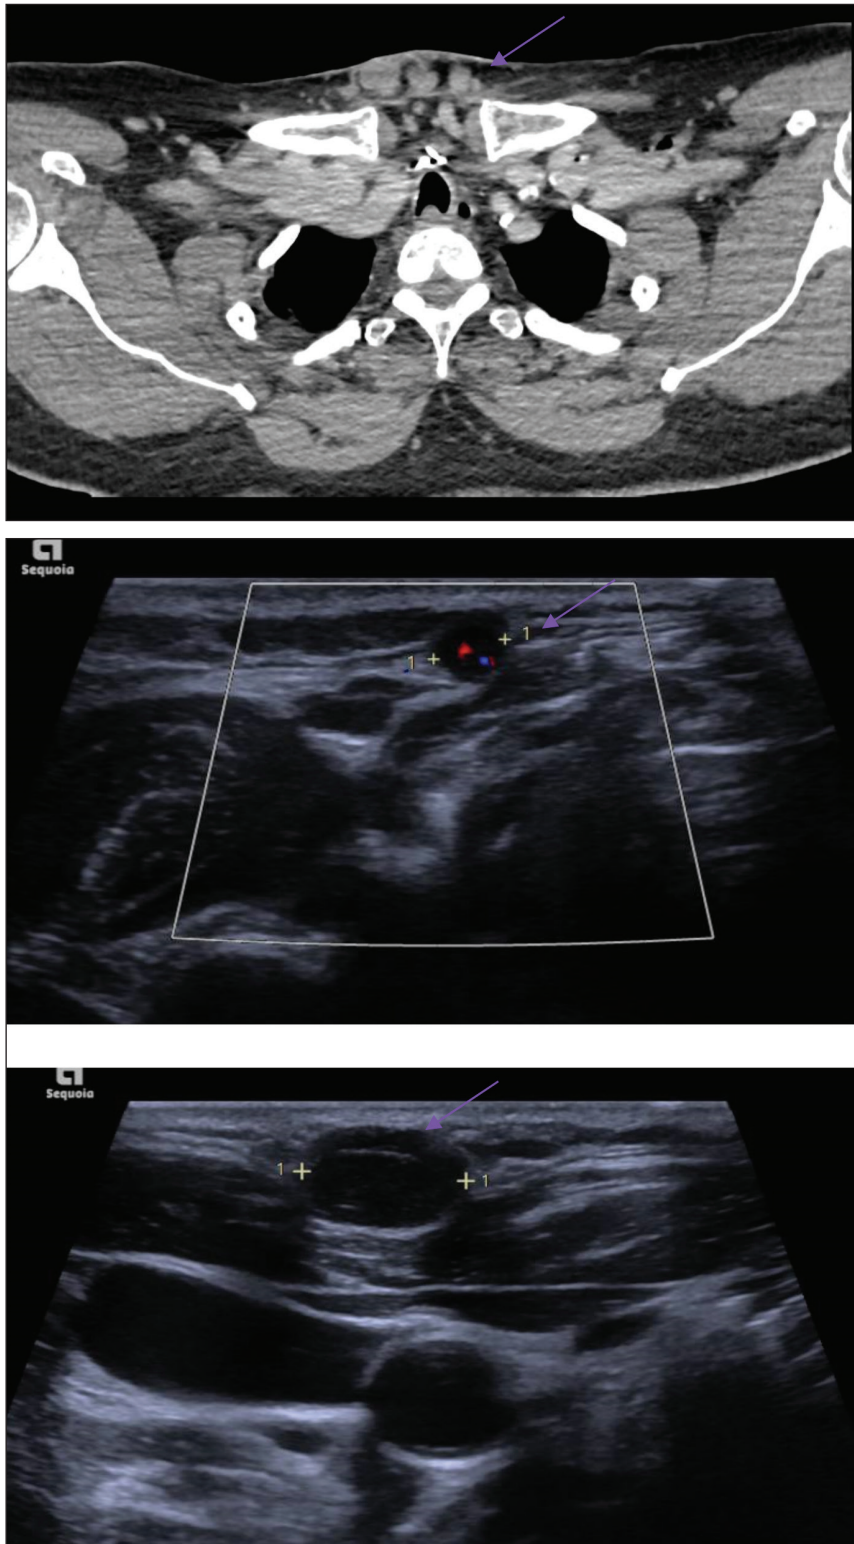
A - Axial CT demonstrating multiple subcutaneous deposits within the sternal notch. B - Two US images highlighting multiple small subcutaneous metastatic deposits.
